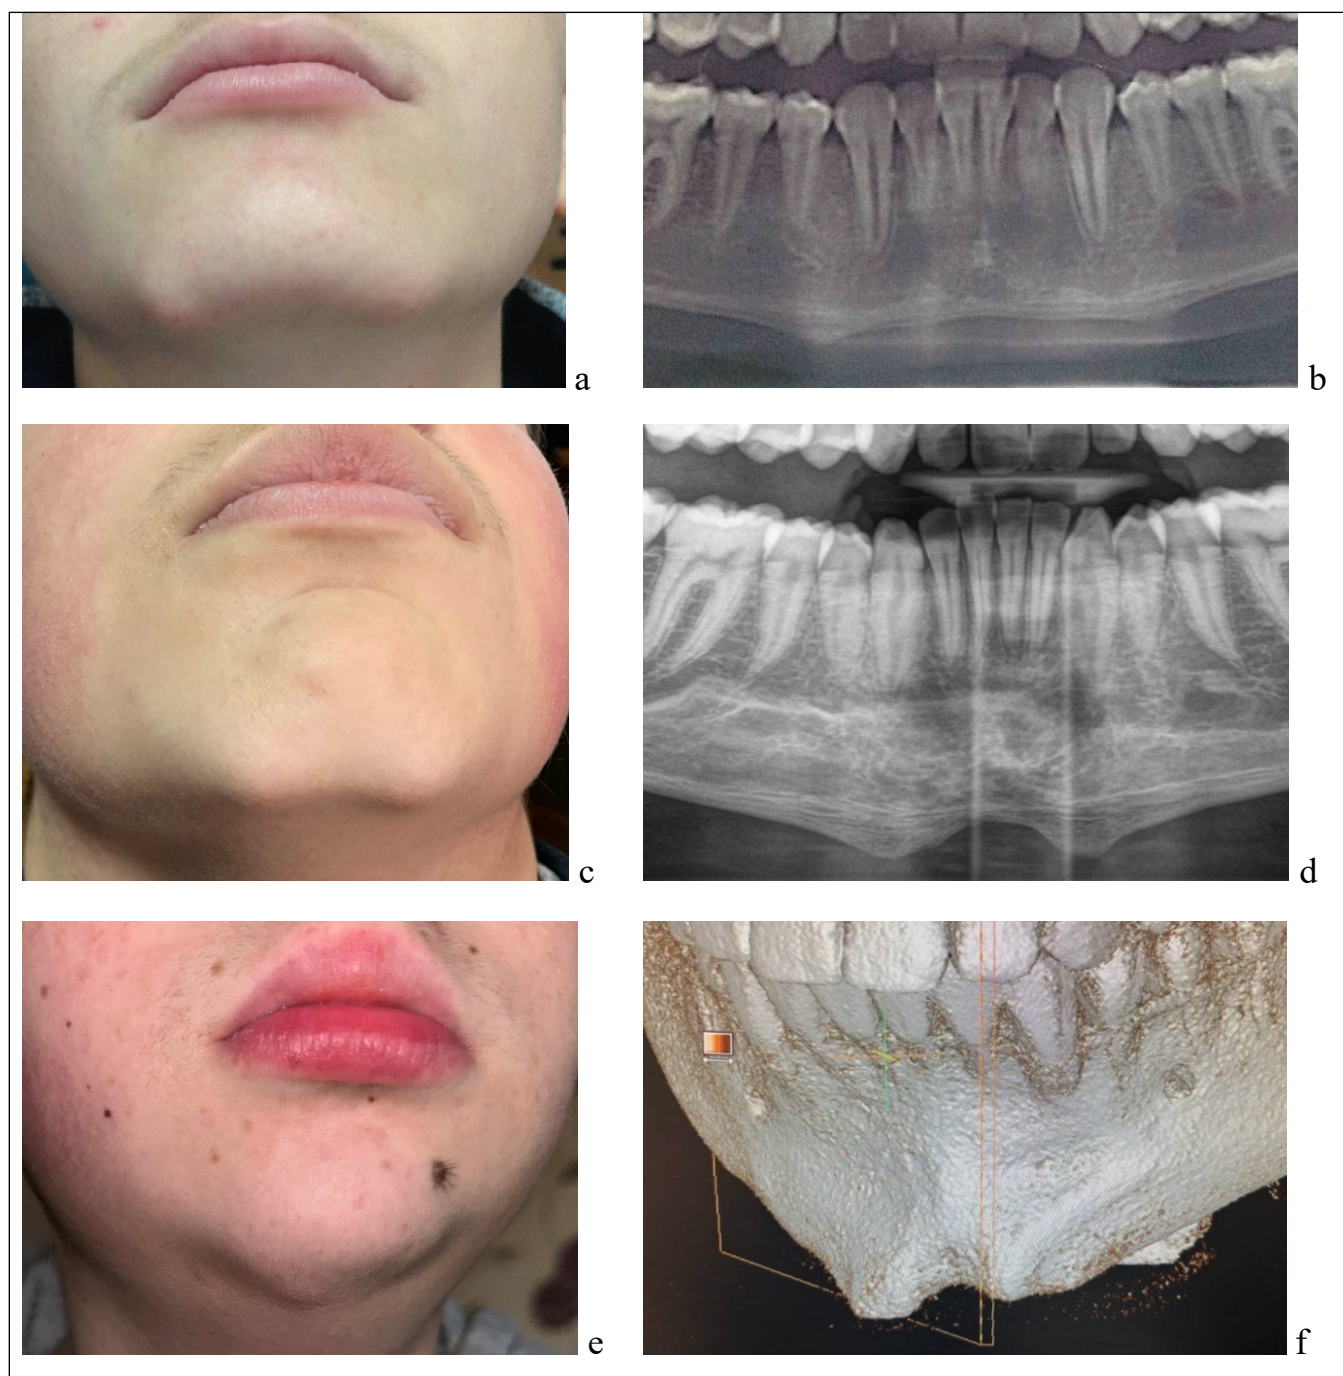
Overall appearance (a, c, e) and fragments of orthopantomograms (b, f) and computed tomography with 3D visualization (f) of children with “bony spurs.” The “extraoral protrusions” in the submental area and the corresponding bone changes in the mandible region are clearly visible
